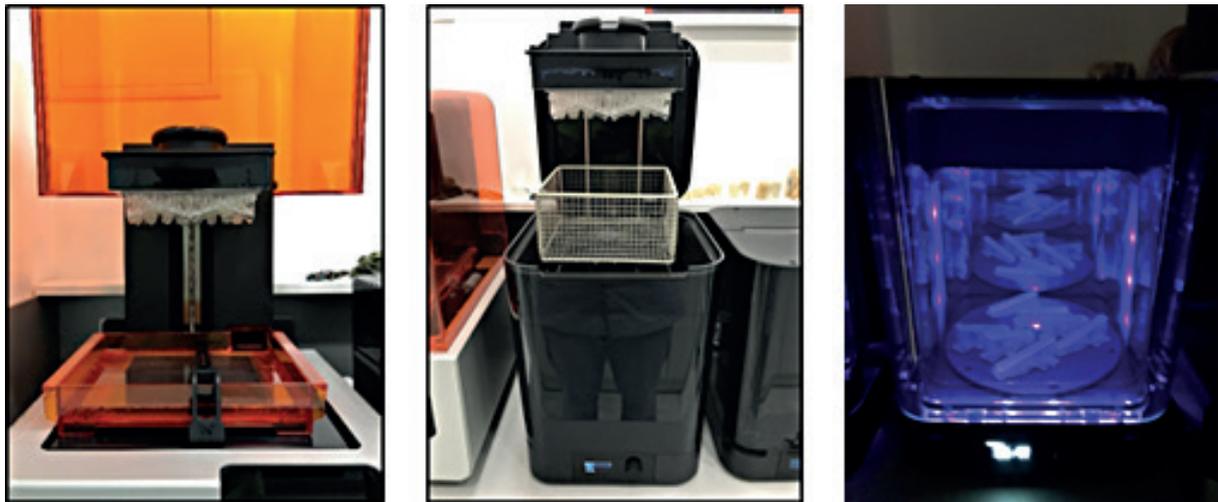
(a) Form 2 3D printer; (b) Form Cure Ultrasonic Bath; (c) Form Cure ultraviolet curing device
